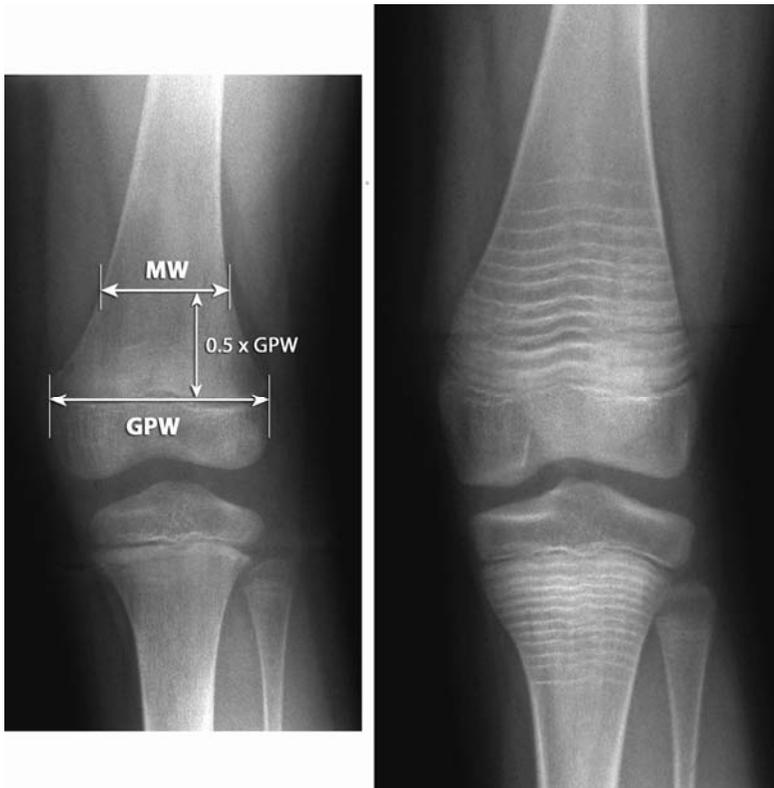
The metaphyseal index at the distal femur can be calculated as the ratio between metaphyseal width (MW) and growth plate width (GPW). Shown are radiographs of a boy with OI type I that were taken at the start of pamidronate treatment (left; age 7.3 years; metaphyseal index, 0.59) and 3.6 years later, when 11 pamidronate cycles had been given (right; metaphyseal index, 0.72). All expected 11 transverse lines are visible in the proximal tibial metaphysis as well as in the distal femur (From: Land C, Rauch F, Glorieux FH. Cyclical intravenous pamidronate treatment affects metaphyseal modeling in growing patients with osteogenesis imperfecta. *J Bone Miner Res* 2006; 21: 374-379).
